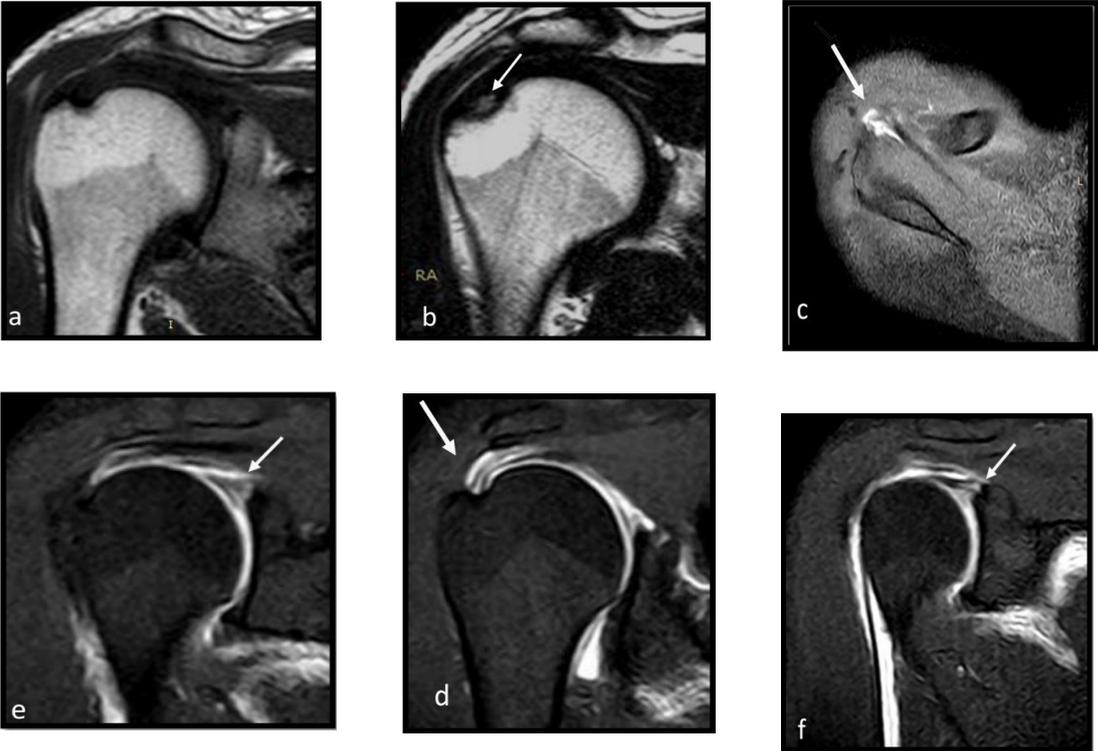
Conventional MRI: Coronal T1(a), coronal T2(b): showed abnormal signal in the articular surface of the supraspinatus muscle (arrow). MRI arthrography: axial T1 fat suppression(c) and coronal T1 fat suppression(d): showed contrast filling in the substance of the supraspinatus tendon (arrows), while in figure (e): coronal T1 fat suppression shows fraying of the superior labrum, fig (f): showed contrast filling about 7 mm of the intrasubstance of the humeral attachment of the biceps tendon.
